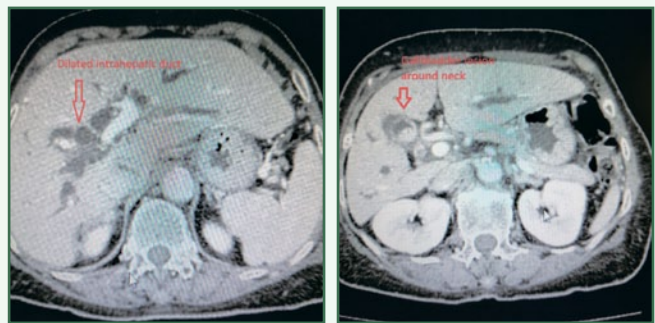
CT scan show dilated biliary tree, gallbladder lesion and gallbladder wall thickening suspicious to be CA gallbladder
